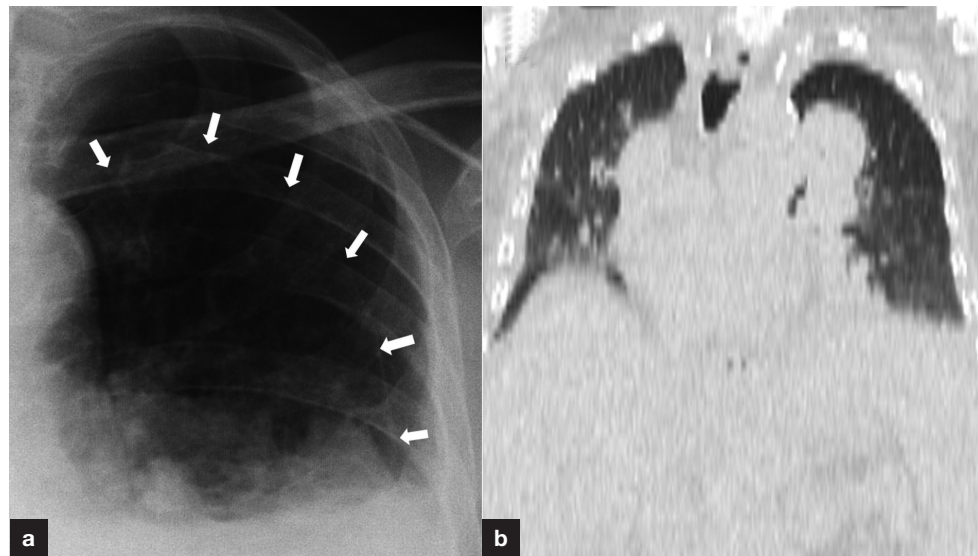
a. Posteroanterior chest X-ray showing a suspicious pneumothorax appearance on the left hemithorax (arrows). b. Coronal computed tomography scan confirming the absence of pneumothorax.
